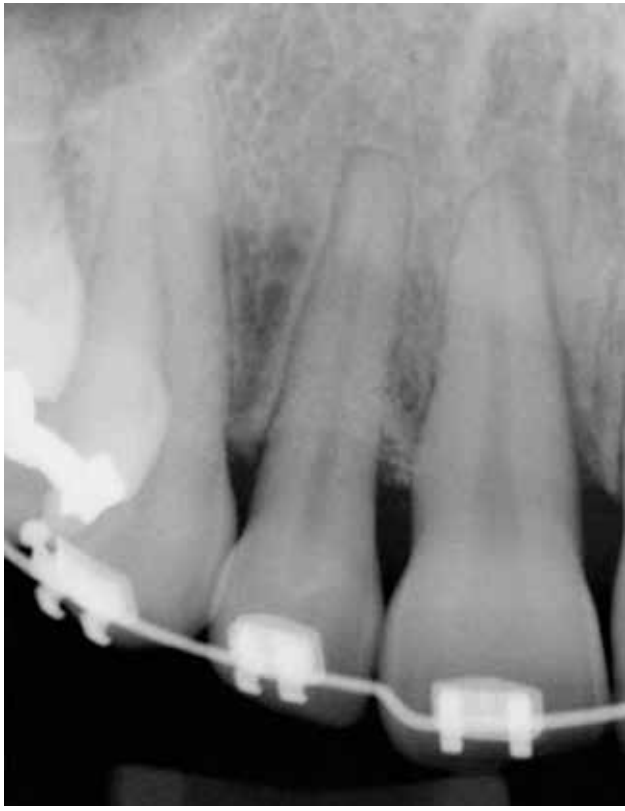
At completion of orthodontic treatment, dense osseous crestal profiles with appreciable bone fill were present. However, minor periapical resorption of the right lateral root was noted.
